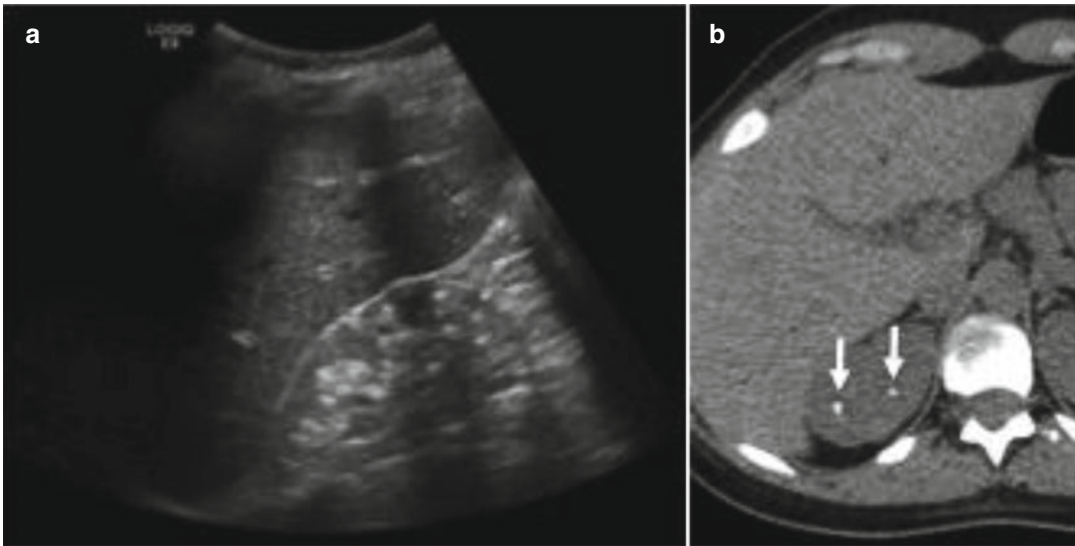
(a) US scan shows cortical and medullary nephrocalcinosis represented by hyperechoic spots diffuse in the renal parenchima; (b) CT examination confirms nephrocalcinosis with hyperdense renal pyramids (*arrow in b*)
